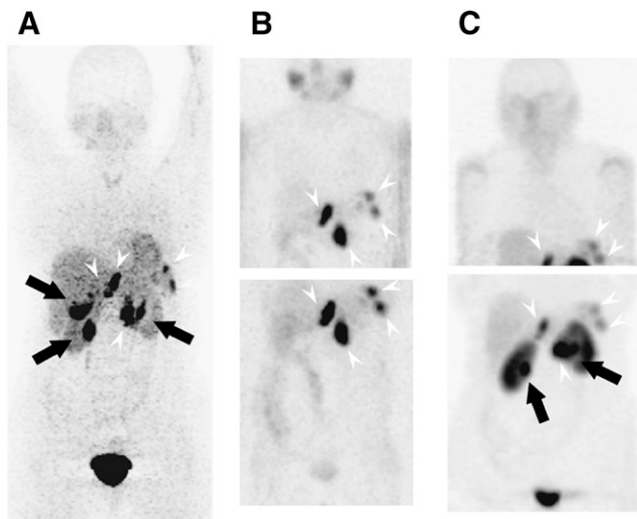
Reprojected ^{18}F -DA (A), 24-h ^{123}I -MIBG (B), and 4-h SRS (C) images of 60-y-old woman with left adrenal PHEO and peritoneal and retroperitoneal metastases (arrowheads). ^{18}F -DA PET and SRS (arrows) show more lesions than does ^{123}I -MIBG scintigraphy.
